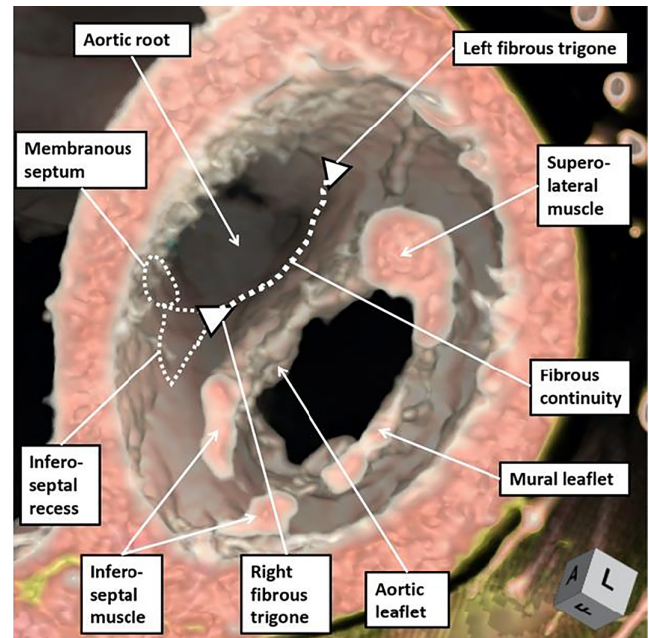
The image shows how the left ventricle of the human heart can be assessed in terms of its inlet, apical and outlet components. The ventricle has been opened through a superior incision parallel to the anterior interventricular groove. The roof of the ventricle is formed by the area of fibrous continuity between the leaflets of the aortic and mitral valves, which is thickened at its ends to form the right and left fibrous trigones (white triangles with black borders). The outlet component is complex, extending beyond the so-called echocardiographic 'annulus', which in reality is no more than a virtual basal ring, to reach the level of the sinutubular junction. Note the infero-septal recess of the outflow tract, which interposes between the leaflets of the mitral valve and the septum.
